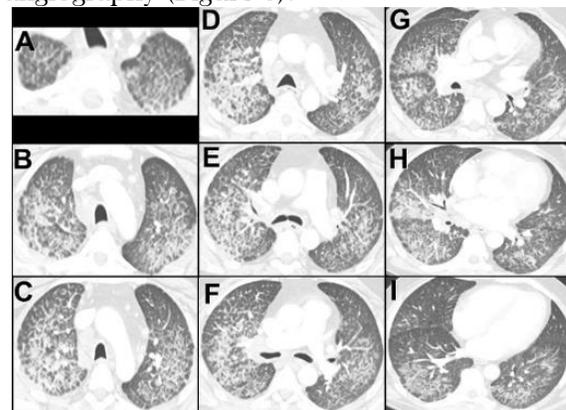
Axial unenhanced CT obtained 9 months after initial presentation. Click [here](#) to open Figure 6 in a new, enlarged window. Click [here](#) to open a video of Figure 6.
